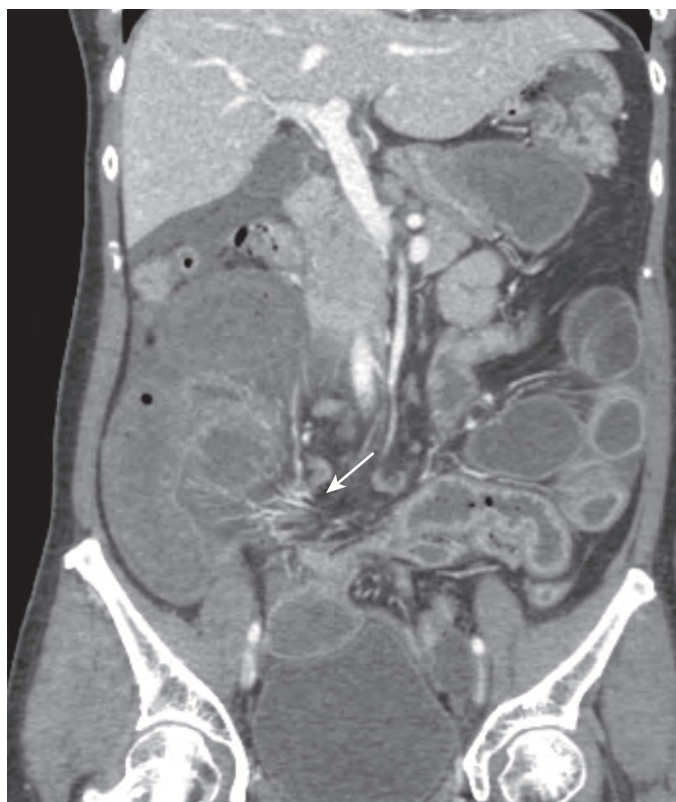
Closed loop obstruction leading to small bowel strangulation. Coronal contrast-enhanced CT image demonstrates multiple dilated loops of small bowel, many of which appear tethered and radiating toward a central point (arrow) indicating closed loop obstruction. In addition to several markedly thickened, hyperemic loops of small bowel, several loops of bowel in the right abdomen are poorly enhancing. There is also a small amount of interloop ascites. A strangulated ischemic small bowel was found at surgery.
